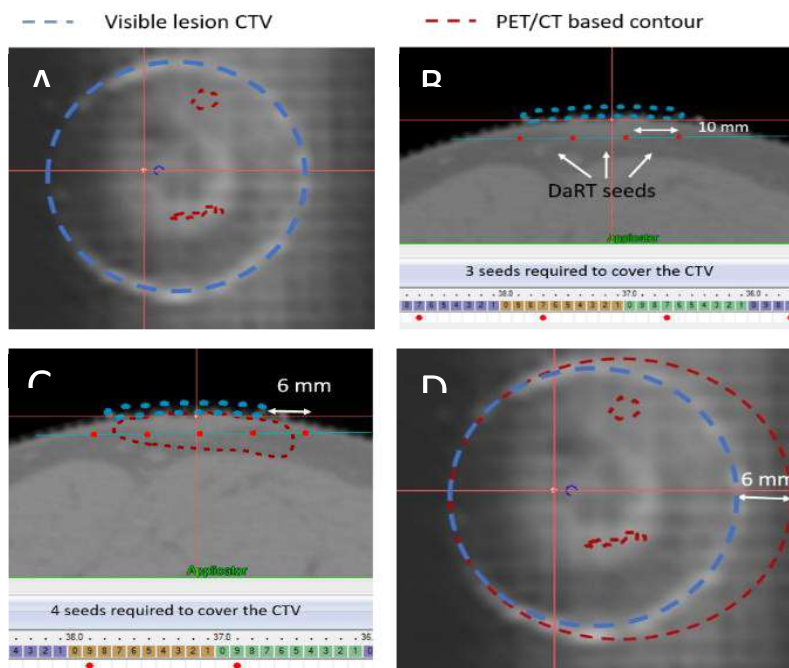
(A) Visible CTV drawn with the radio-opaque marker by the physician highlighted in blue over the radio-opaque trace. (B) Geometrical planning on CT with the TPS with the 1cm long DaRT seeds represented by red dots. The cover-age of blue CTV is achieved with 3 seeds (C) The PET/CT-based CTV is depicted in red alongside the blue CTV, indicating subcutaneous tumor invasion and the necessity for four DaRT seeds for
